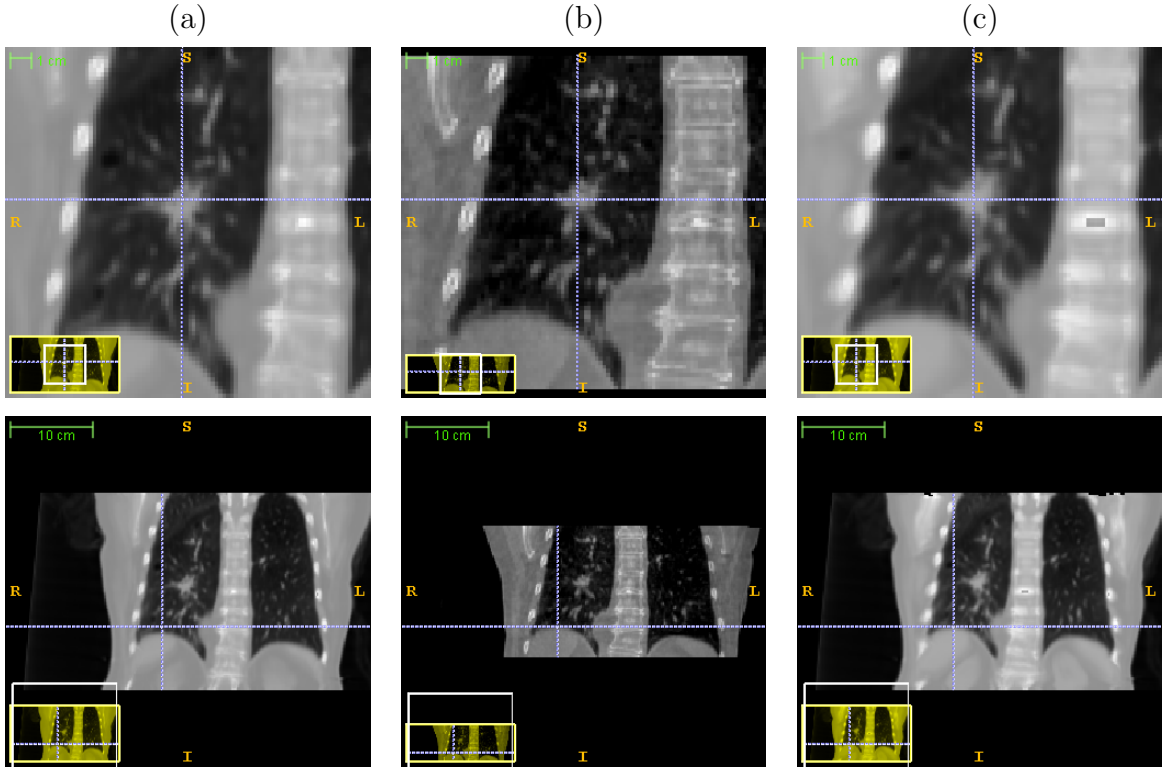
The same 3-space lines in (a) the mean CT, (b) the reconstructed CBCT at the EE phase and (c) the estimated CT of the same lung dataset used in figure 5.5.6(b). Upper row: lines indicate the tumor centroid in the CBCT at the EE phase; lower row: lines indicate the diaphragm contour in the CBCT at the EE phase.
